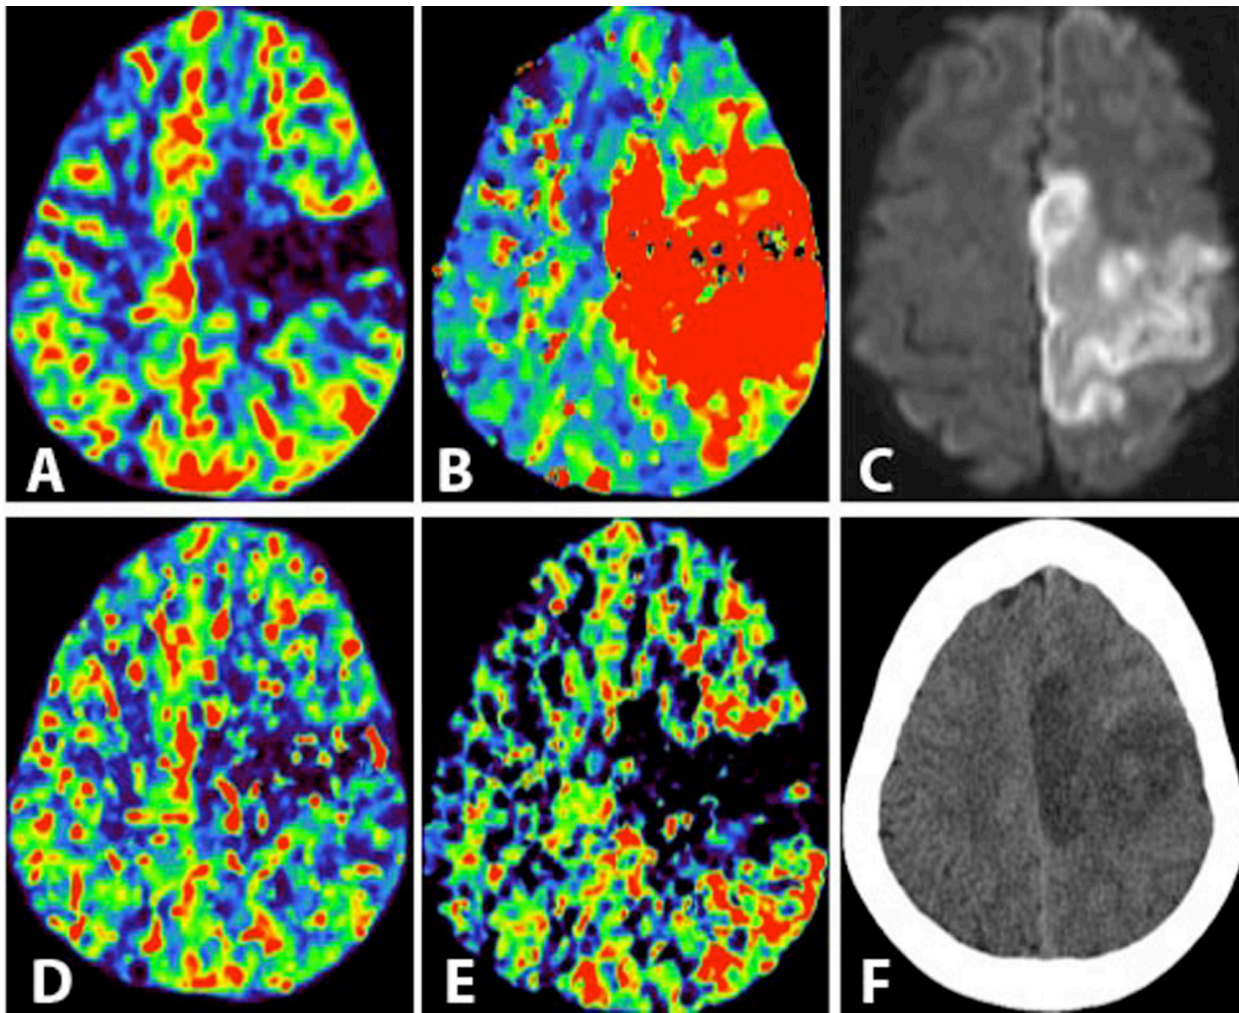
CTP map demonstrating decreased CBV in the left MCA territory (a) and increased TTP in the entire left MCA and distal part of the ACA (b). Follow-up diffusion-weighted MRI (c) 18 h later showing the final infarct in the left MCA and ACA territory matching the area of decreased MTT on initial imaging. MTT maps reveal an area of decreased MTT potentially representing the IC and larger area of increased MTT showing ischemic penumbra (e); for comparison CBF is shown in (d). Follow-up noncontrast CT scan three days later showing the infarcted brain tissue (f).
